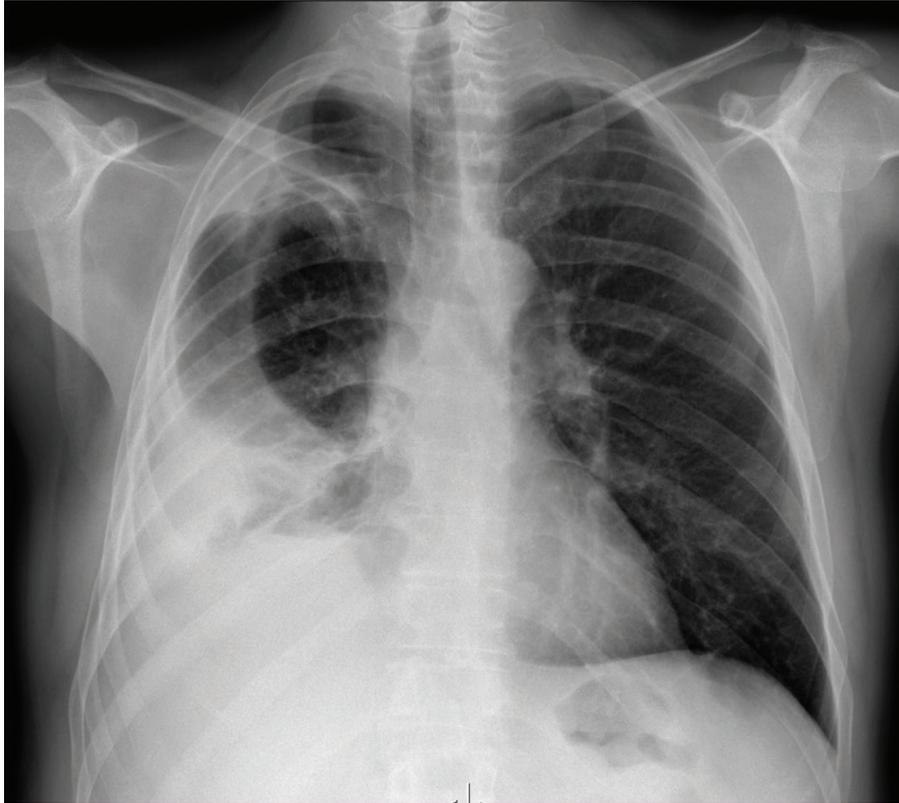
Posteroanterior chest radiograph shows a large amount of fluid in right pleural cavity
